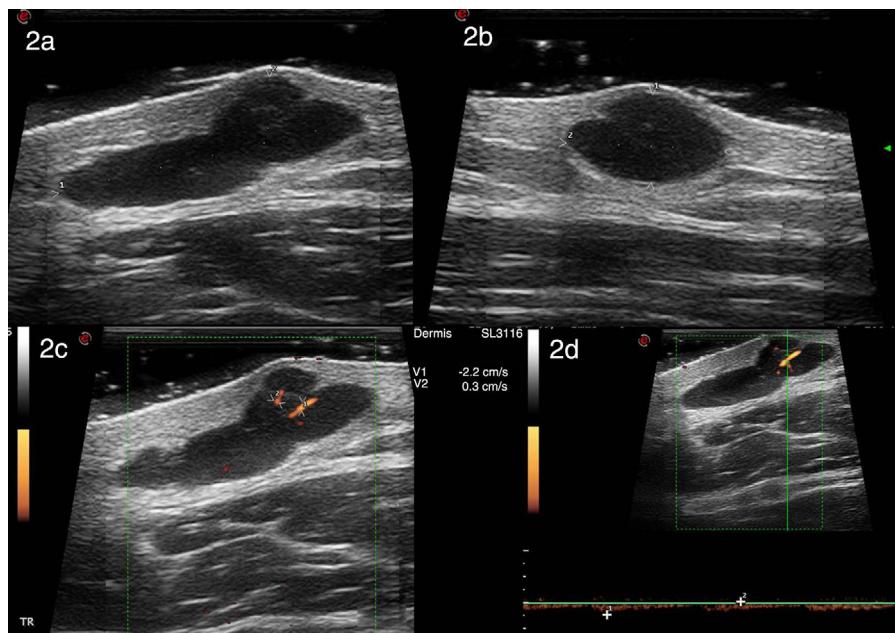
High-resolution ultrasound with a 22-MHz probe (MyLab class C, Esaote) reveals a well-defined polylobulated anechoic image with an internal septum located in the dermis and hypodermis. Positive enhancement was observed. The image measured 11.9 mm along its transverse axis (A) and 5.9 mm along its longitudinal axis (B). Power Doppler revealed sparse intralesional vascularization with arterial and venous vessels measuring between 0.2 and 0.4 mm in diameter (C). Spectral Doppler showed that the arterial vessels had a maximum systolic peak of 2.2 cm/s (D).
